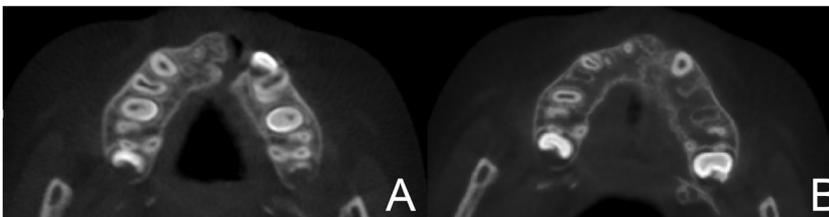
Axial cone beam computed tomography images of a patient with a unilateral complete alveolar cleft repaired with β -TCP: (A) preoperative situation; (B) 1 year postoperative situation.
